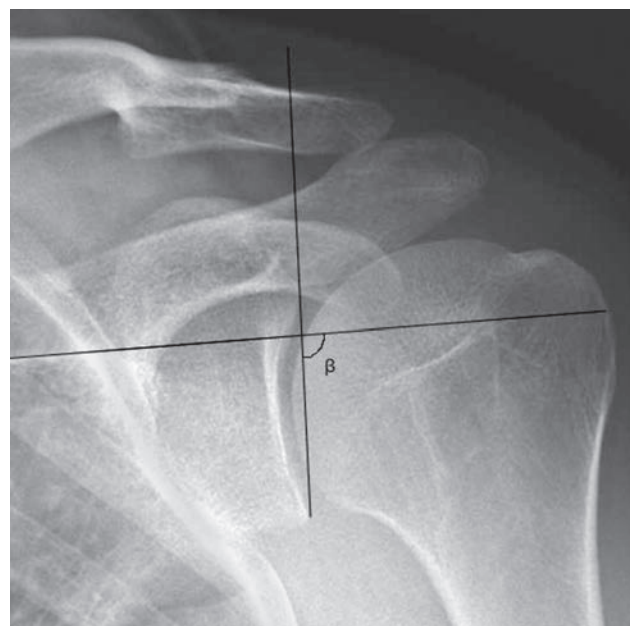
X-ray showing the measurement of the β angle (the angle formed by the intersection of the line passing through the floor of the supraspinatus fossa and the line passing through the articular surface of the glenoid fossa).
